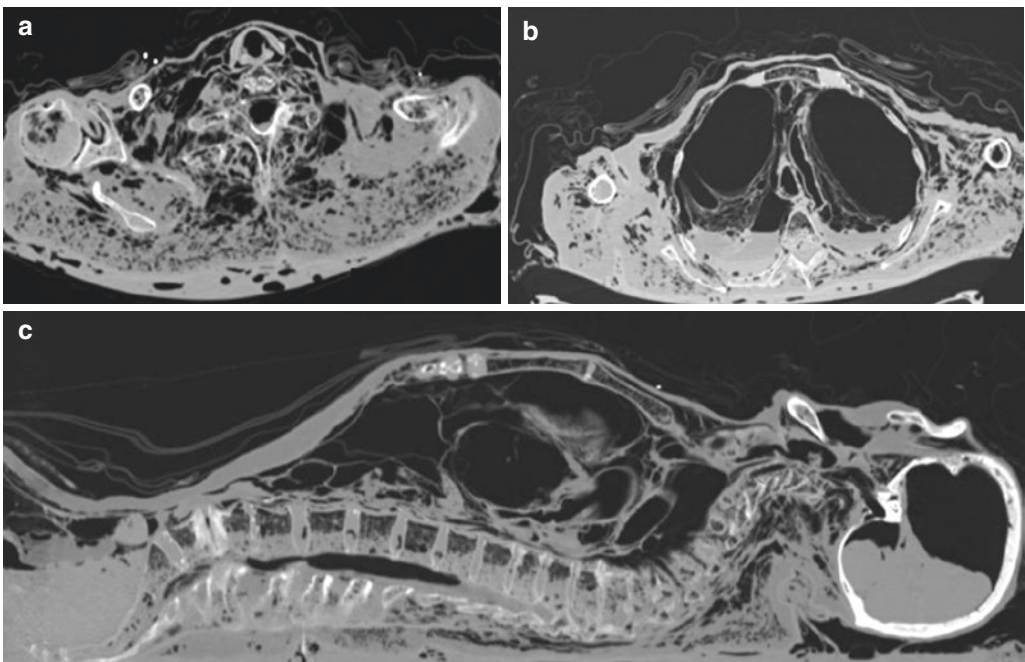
Postmortem CT of an exhumed body in axial view (a, b) and sagittal (c). Imaging demonstrates natural decomposition processes of organs and bones after years
